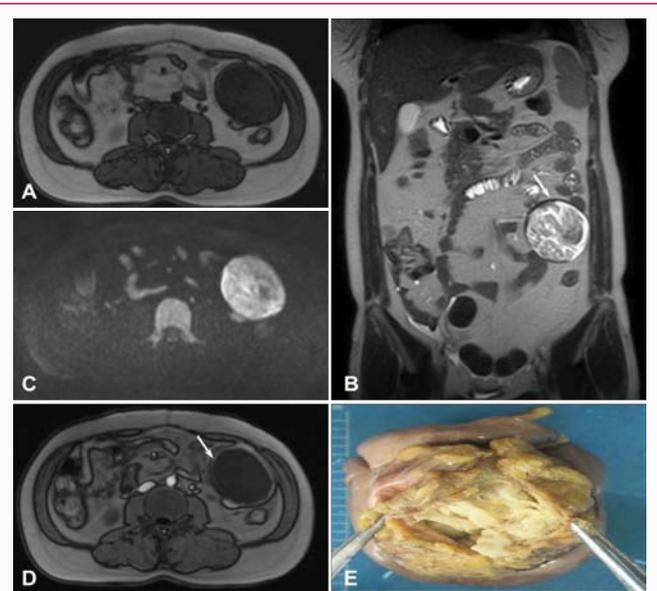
A 38-year-old woman with a mass in her left middle and lower abdomen 18 months after caesarean section. A-D: MRI plain and enhancement scan showed a mass in her abdomen with complete capsule at the margin (white arrows), obviously ring enhancement was observed in the capsule, but no enhancement was found inside. E: Postoperative view of the gross shows there was a retained surgical gauze foreign body in the mass.
